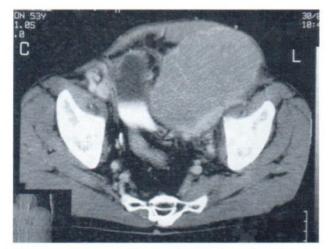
CT scan post I.V. contrast at the same level of 2A showed that most of the mass enhanced homogeneously except the hypodense areas which could be due to tumor necrosis.
